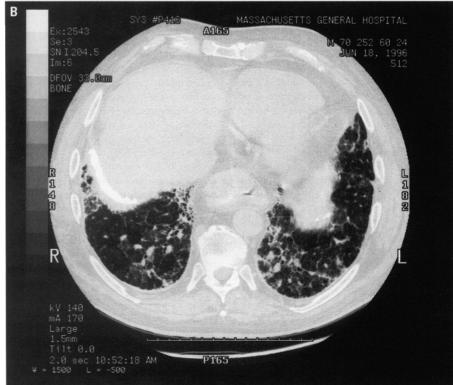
High-resolution computed tomography (HCRT) scans obtained in (A) 1991 and (B) 1996.
